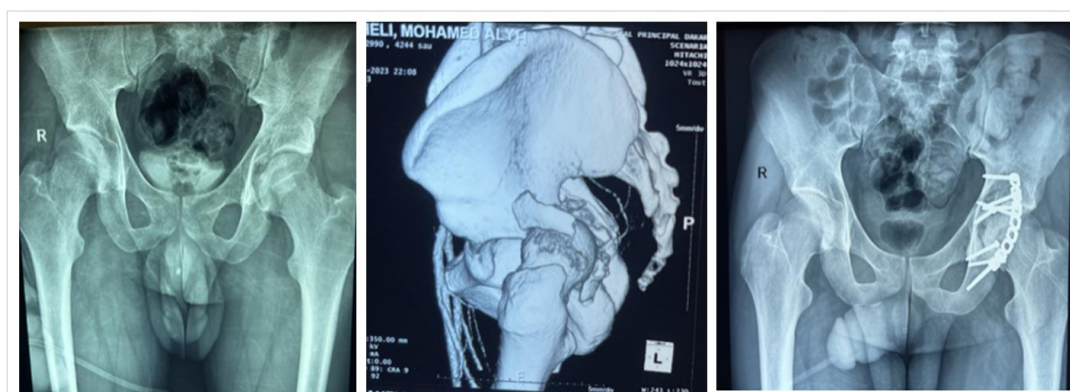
Radiographical Aspect of Acetabular Posterior Wall Fracture Managed with a Posterior Plate.
